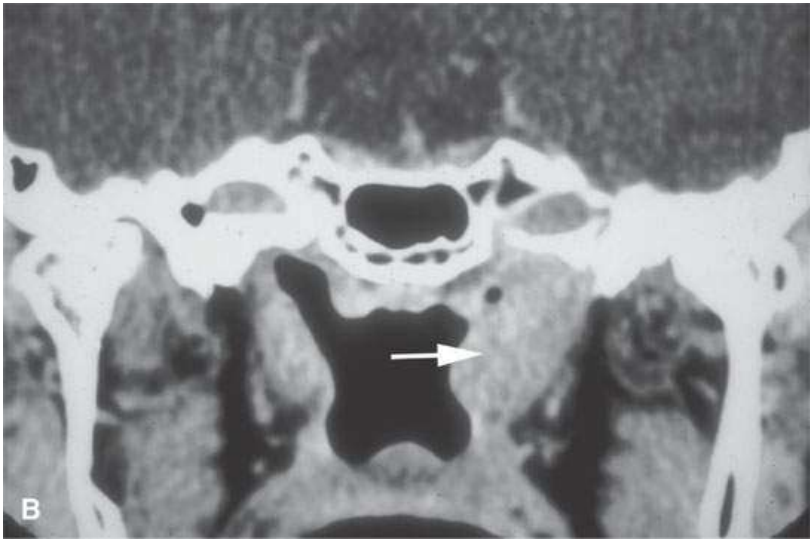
Contrast-enhanced computed tomography in the axial (A) and coronal (B) planes of Wegener granulomatosis of the nasopharynx mimicking nasopharyngeal carcinoma as an infiltrating mass surrounding the eustachian tube (arrows).
